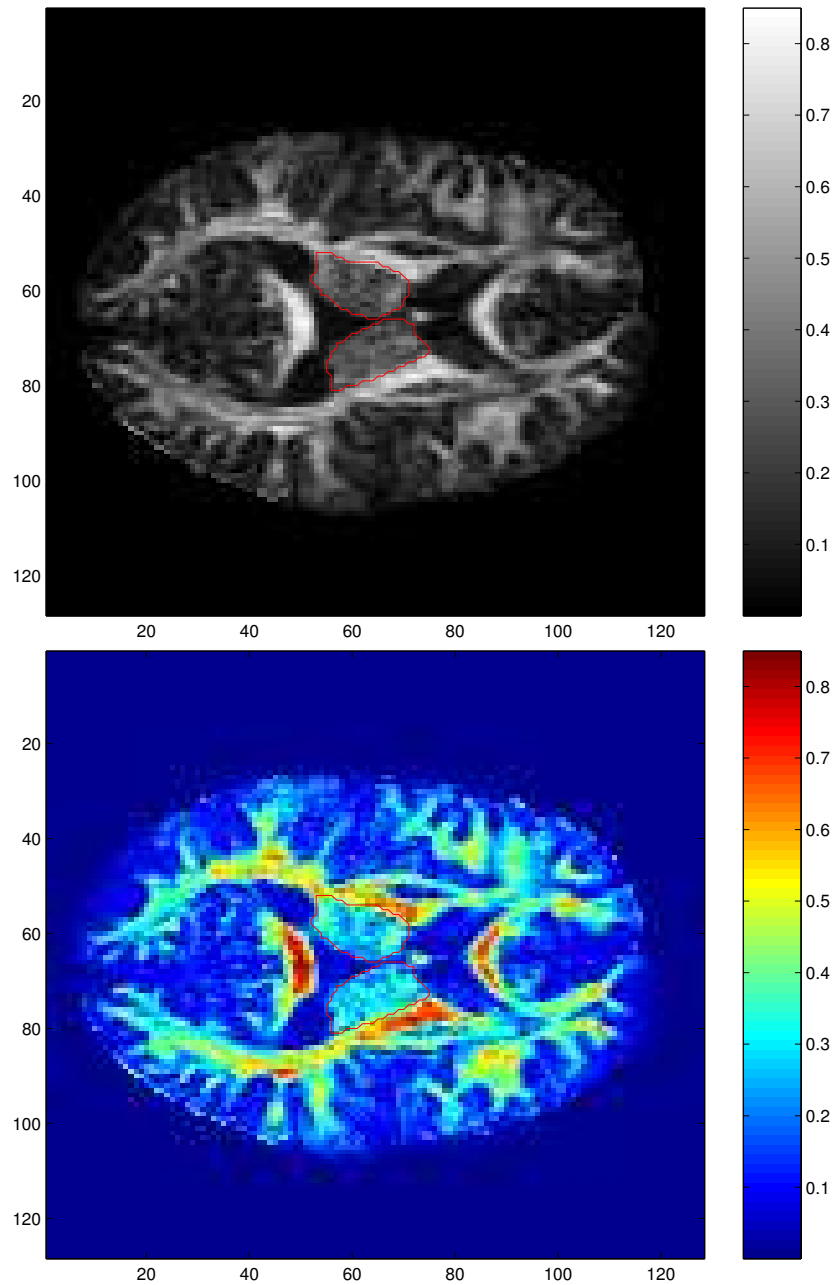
Fractional Anisotropy maps of a DT-MRI, axial slices. Same cut (slice #19) in black and white, and colours. The thalamus is the area inside the red contours, in the center of both images.
